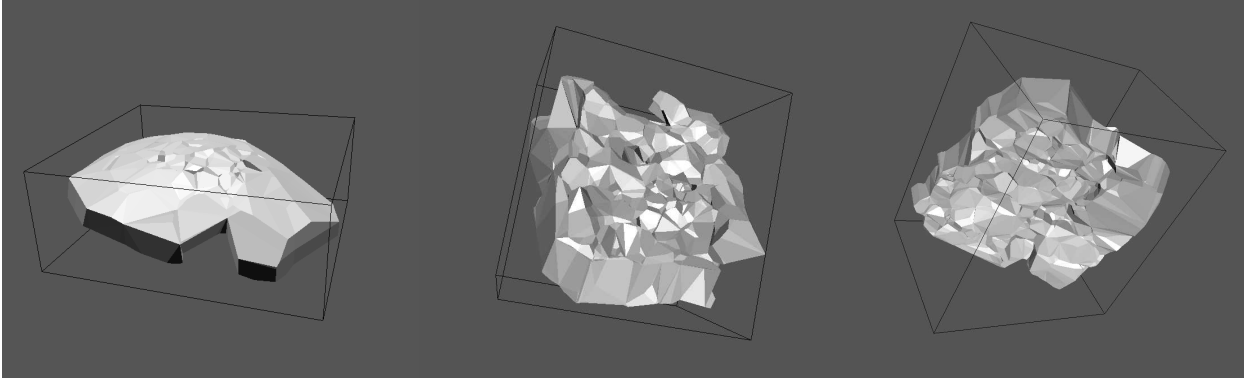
Results of skull surface reconstruction based on ultrasound scanning. While the measurements of the upper surface (left) are reliably localized, the lower surface has a lower signal-to-noise ratio that initially resulted in a more crumpled surface reconstruction (center). However, with proper perpendicular orientation of the probe w.r.t. the skull surface, the lower surface could be reconstructed with a higher quality (right) [Stolka08].
